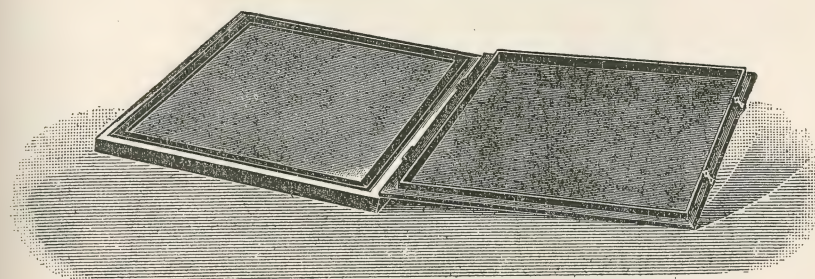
Shallow metallic box for holding plates as described in text with exclusion of diffused secondary X-rays.
